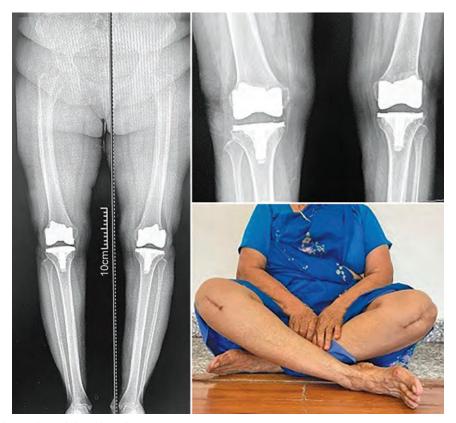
Postoperative radiographs and clinical result
